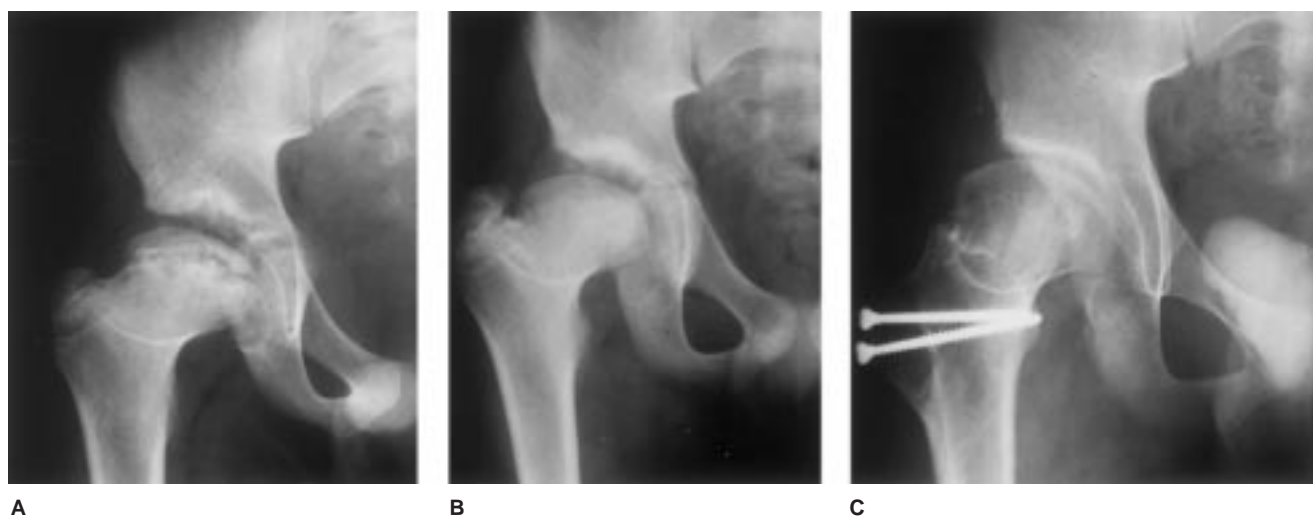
Coxa vara due to vascular injury and trochanteric overgrowth. A, Radiograph obtained after closed treatment of hip dislocation demonstrates coxa breva, plana, and vara. The capital physis is narrowed and irregular. B, Coxa vara progressed as the greater trochanteric physis continued to grow and the femoral physis closed. There was no change in the distance from the lesser trochanter to the top of the femoral head, but the distance from the lesser trochanter to the top of the greater trochanter increased. C, Distal transfer of the greater trochanter improved hip mechanics.
